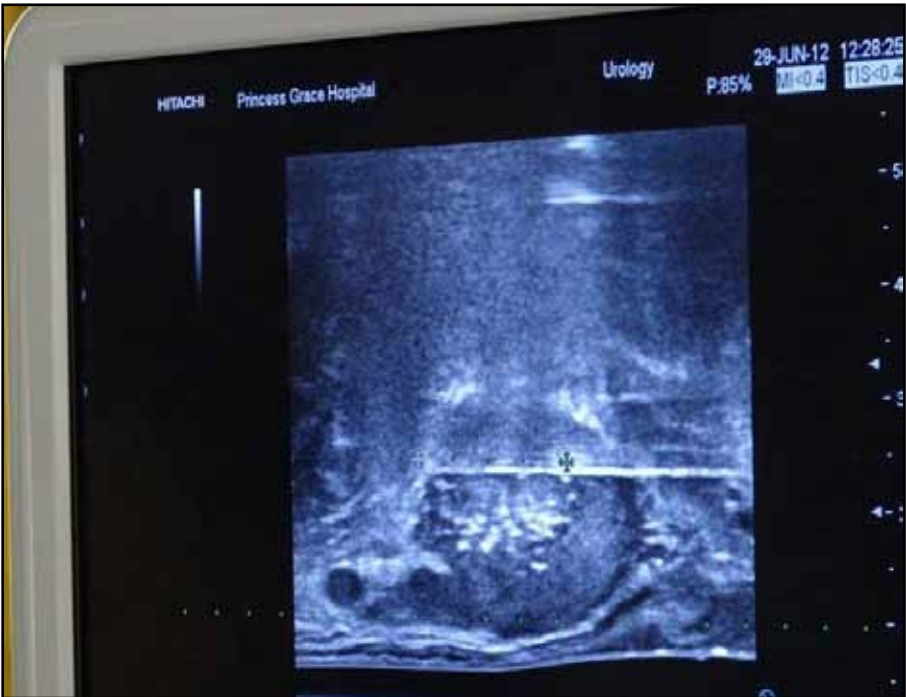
Irreversible electroporation (NanoKnife) therapy. Placement of electrodes under ultrasound guidance
